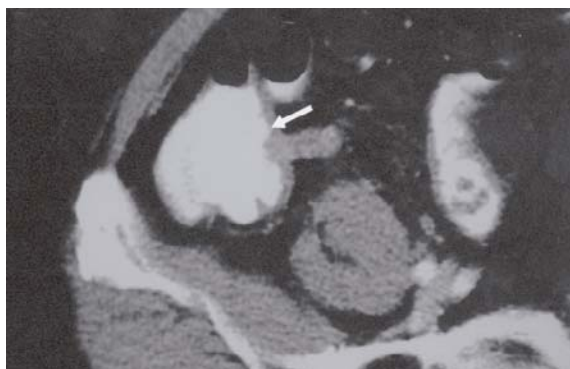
Enhanced axial CT image shows an arrowhead-shaped collection of contrast near the orifice of the appendix, the so-called "arrowhead" sign (arrow)
